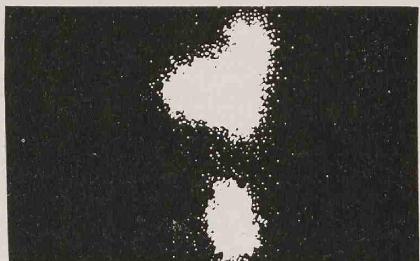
133 Xenon scintigram of right frontal and maxillary sinuses.
